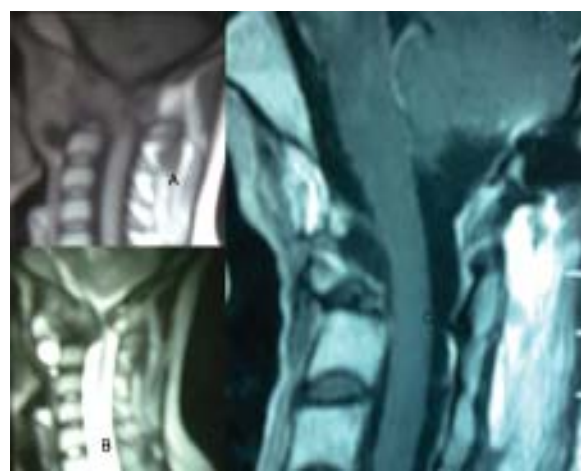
A-MRI of CV junction saggital section T1W image, B-MRI of CV junction saggital section T2W image showing multiple cystic lesion compressing cervico- medullary junction. C-Postoperative MRI saggital section T1W image showing no residual cyst.
